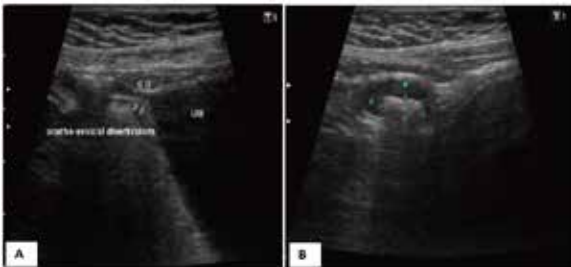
A&B shows ultrasound images of patent uracho-vesical diverticulum on right, on left showing calculus in urachal diverticulum
